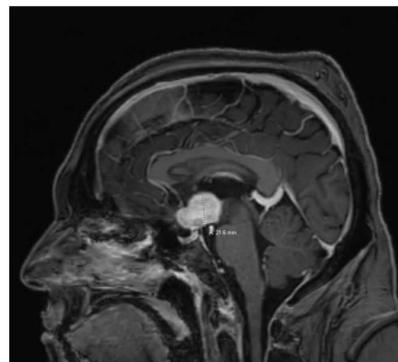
(above left) MRI of head 21.6mm suprasellar mass which appears to be centered on the pituitary stalk neural hypophysis Mass effect upon the hypothalamus and optic chiasm
